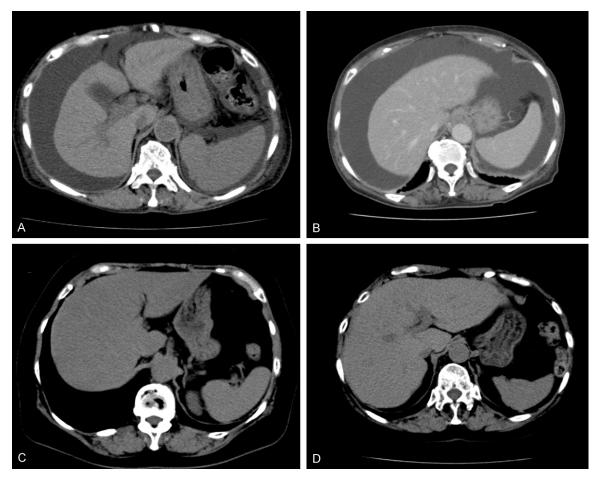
Computed tomography findings of the four cases. A. Case 1. Atrophy of liver, splenomegaly, and ascites suggest cirrhosis. B. Case 2. Findings almost identical with Case 1 suggest cirrhosis. C. Case 3. The low-density of liver indicates fatty change. D. Case 4. No significant change is seen in the liver.
